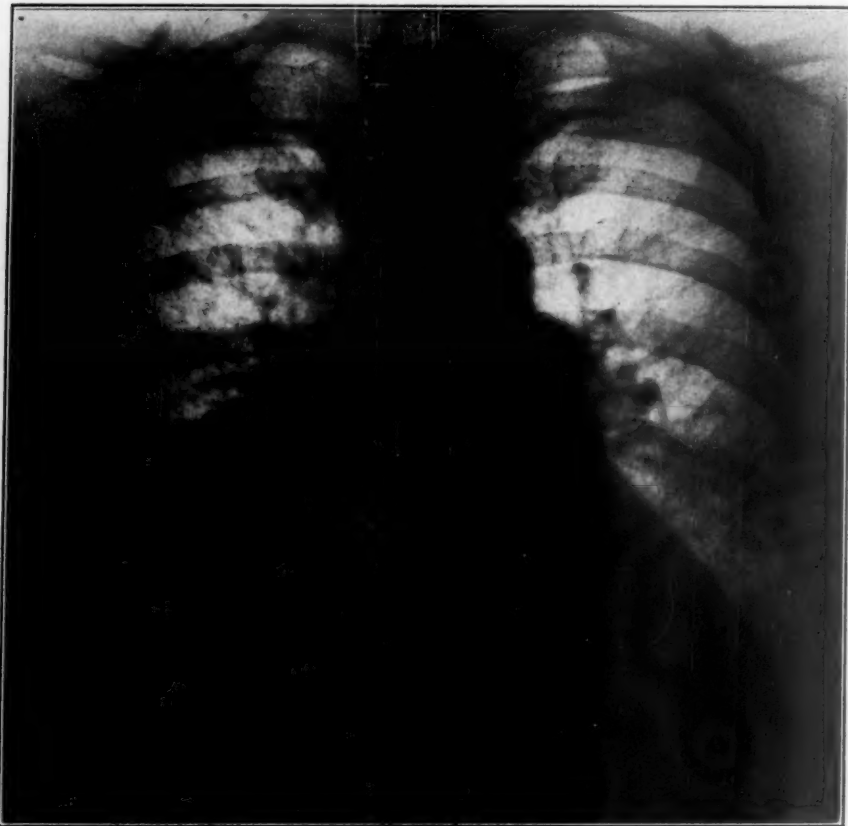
Roentgenogram taken September, 1929. Note the generalized enlargement of the cardiac shadow, and particularly of the pulmonary conus.
